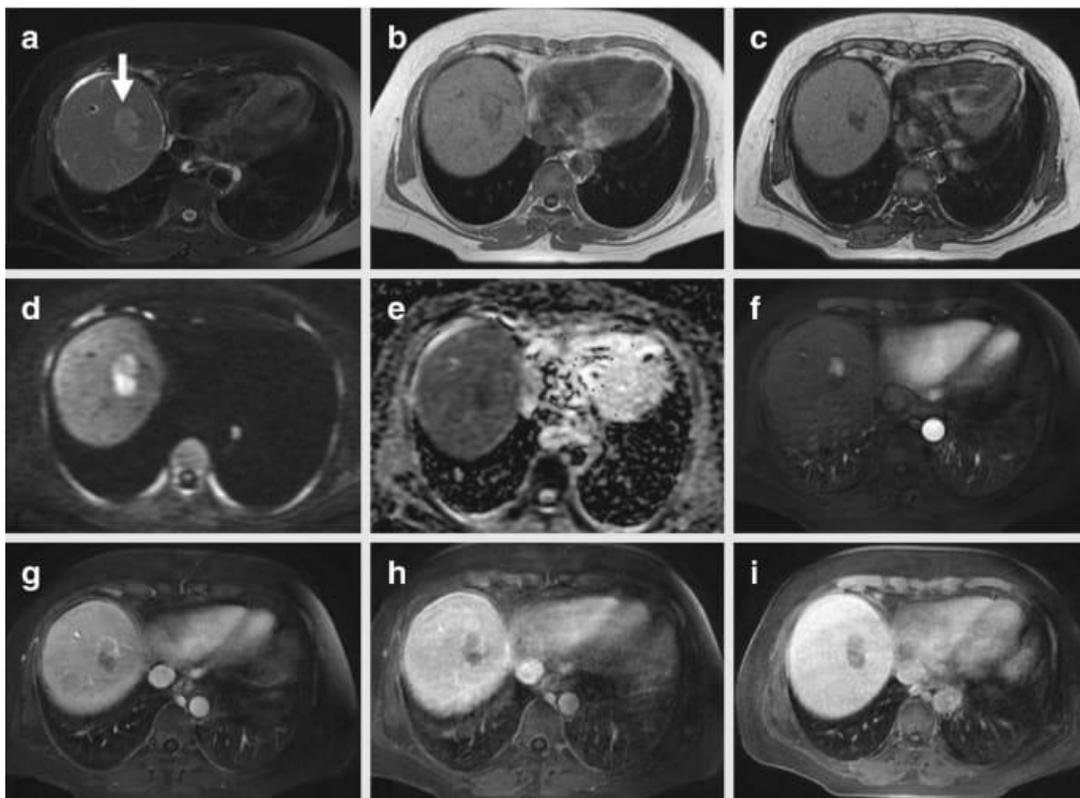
(a–c) A 3-cm nodule is appreciable on segment 8 (white arrow), mildly hyperintense on axial T2-weighted fat saturated (a), partially hyperintense on T1-weighted in-phase gradient echo (GRE) (b) with a partial signal drop-out on axial out-of-phase GRE (c) as expression intralesional fat. (d, e) Diffusion-weighted imaging (d), and apparent diffusion coefficient map (e) show lesion restriction related to hypercellularity. (f–i) Axial T1-weighted fat-saturated sequence in the arterial phase shows intense arterial wash-in of the upper portion of the nodule (f), with wash-out in the portal venous (g) and delayed (h) phases and lack of contrast agent uptake in the hepatobiliary phase (i).
